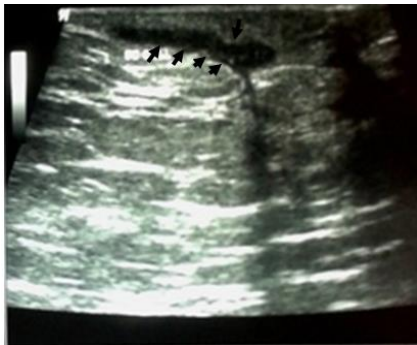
Breast ultrasonography shows an ill-defined, irregular tubular, hypoechoic lesion (black arrows), consistent with IGM.
